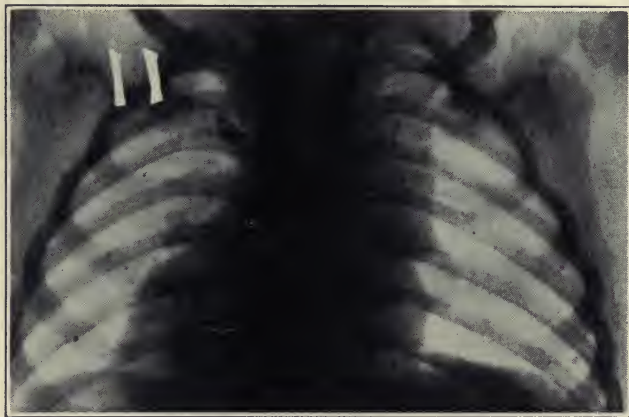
Roentgenogram made Jan. 17, 1920, showing return of decided shadow in thymic region, especially on right side, and practically identical with shadow shown in Figure 1. Note again the presence of the same sharp, angular projection at the right lower end of shadow.
